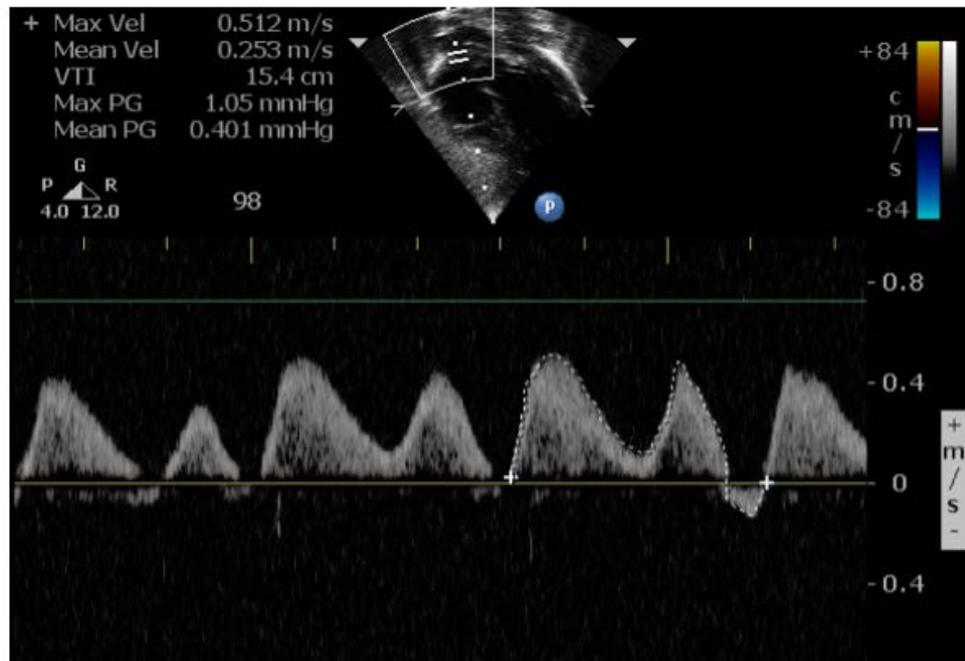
Ultrasound imaging depicting the measurement of blood flow through the superior vena cava by pulsed wave Doppler.
